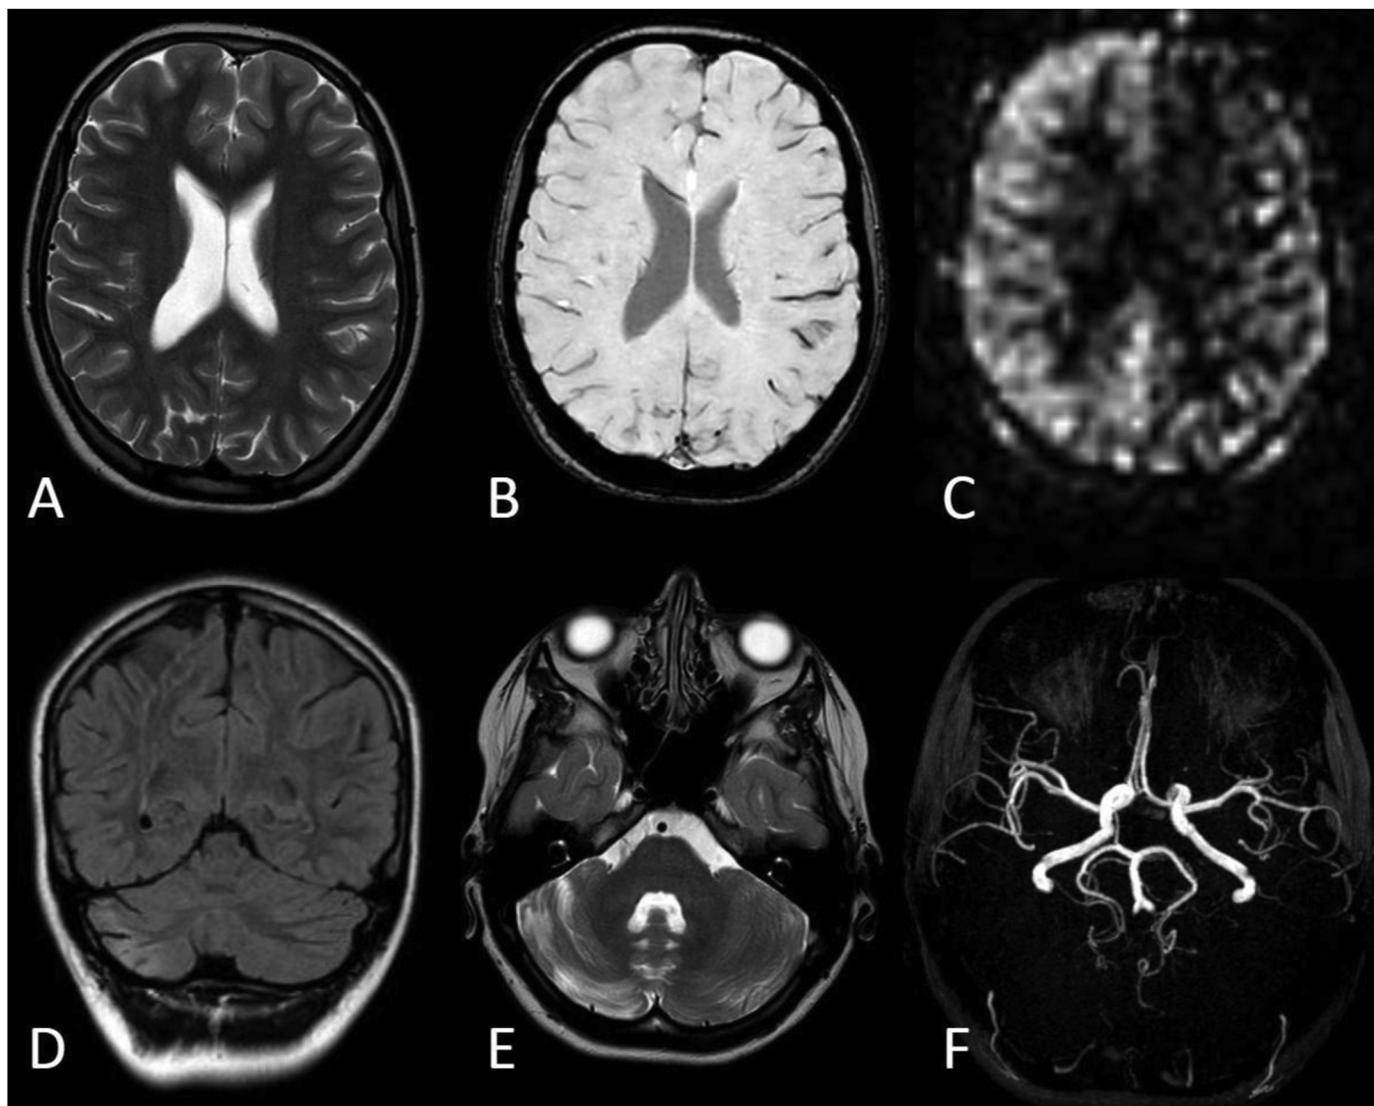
Axial T2-weighted (A), susceptibility-weighted imaging (B), and pseudocontinuous arterial spin labeling (C) images at the level of the middle cells of the lateral ventricles show no evidence of parenchymal lesions in (A) and prominence of some venous structures in the area of the left cerebral cortical sulci (B), associated with hypoperfusion on the left side, more evident in the frontal lobe (C). Coronal fluid-attenuated inversion recovery (D) and axial T2-weighted images (E) show cortical gliosis and atrophy of the right middle cerebellar folia. The distal middle cerebral artery branches are asymmetrically represented on MRA (F), being less evident on the left side.
